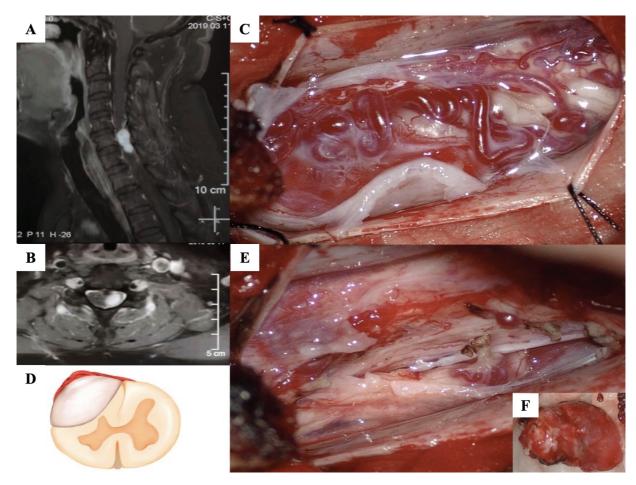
En bloc resection of a cervical spinal cord hemangioblastoma. Contrast-enhanced T1-weighted sagittal (A) and axial (B) magnetic resonance imaging (MRI) demonstrating a densely enhancing dorsolateral spinal cord lesion at the C6–C7 level. (C) Axial MR images of the extramedullary hemangioblastoma. (D) Intraoperative image showing a well-circumscribed, superficially dorsolateral hemangioblastoma localized in the extramedullary part. (E) Intraoperative image after the removal of the hemangioblastoma. (F) The whole tumor is removed via en bloc resection.
